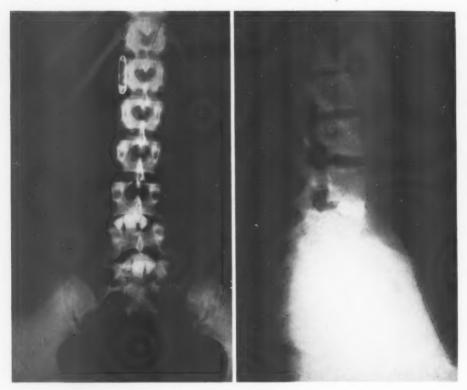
(a) (Left) AP X-ray for position of bone implantations 30 days postoperative.
